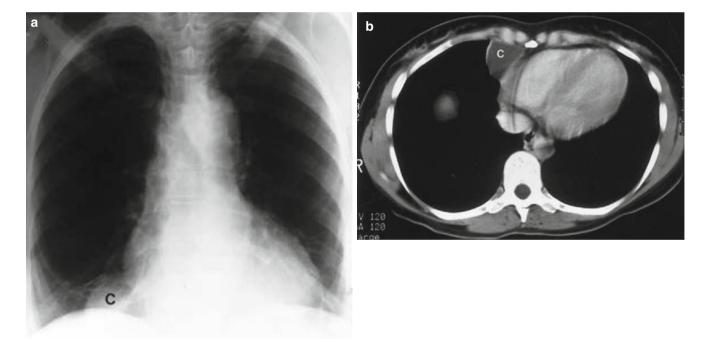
Pericardial cyst. (a) Frontal chest film reveals a smoothly marginated round mass in the right cardiophrenic angle. Main differential considerations for this mass on the chest radiograph include a prominent pericardial fat pad, pericardial cyst, and enlarged lymph nodes
